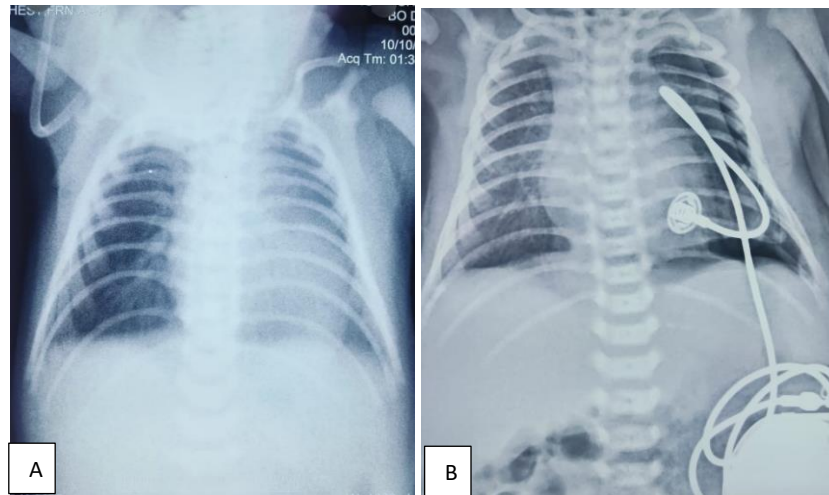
(A and B): Chest x-ray showing mild cardiomegaly, X-ray after pacemaker implantation.
